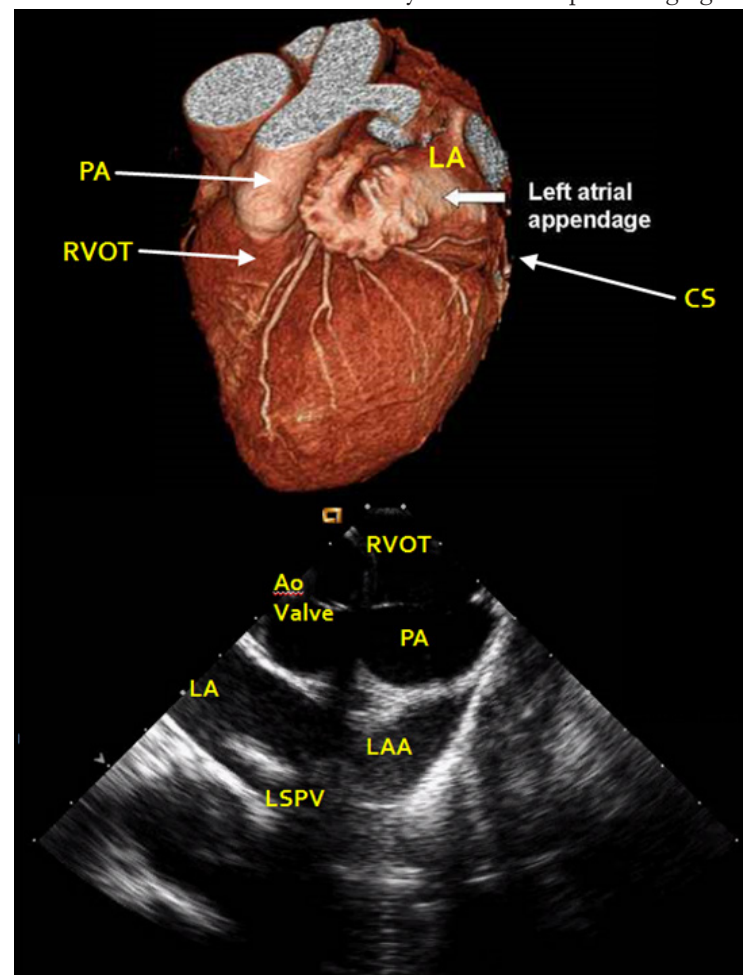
Left atrial appendage imaging. Top: CT representation of a typical left atrial appendage with adjacent structures approachable with ICE. Bottom: Image of left atrial appendage (LAA) obtained with ICE catheter placed in RVOT. LA = left atrium; CS = coronary sinus; PA = pulmonary artery; RVOT = right ventricular outflow tract.
